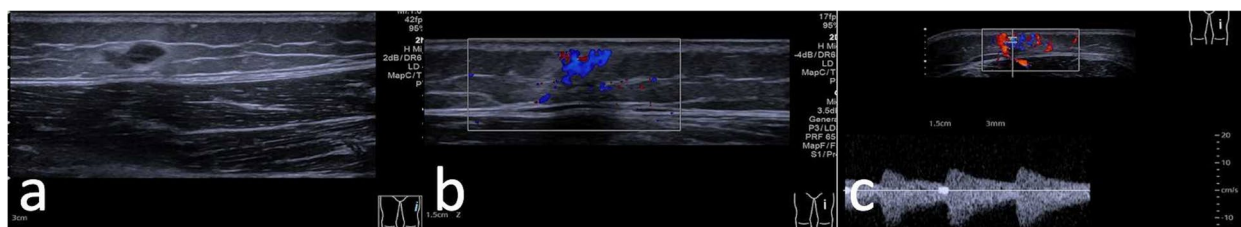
Imaging in a child with SS-LCH. a-b Four hypoechoic nodules of varying sizes in the subcutaneous layer of the left middle thigh (a), and abundant blood flow signals in the nodules on CDFI examination (b). c pulsed wave Doppler (PW) examination indicated low resistance arterial type spectrum
